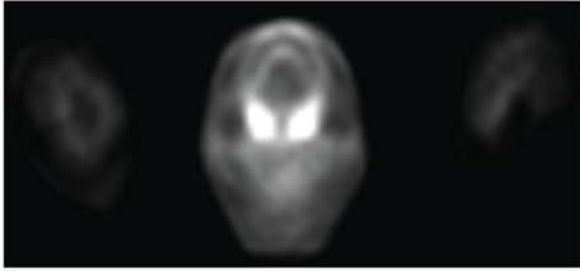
Axial PET scan images obtained after IV injection of 13 mCi of F-18 FDG show increased FDG uptake in bilateral tonsils.
